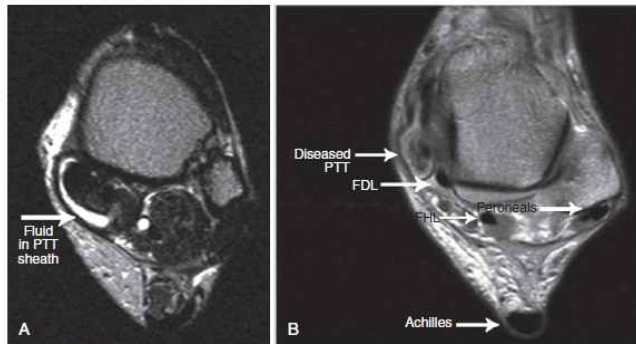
Magnetic resonance imaging is helpful to identify peritendinous effusion (A) and degeneration within the tendon (B).
